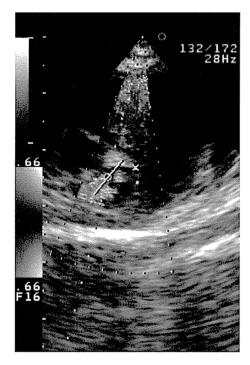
Echocardiography of right ventricular outflow tract. This finding showed the pulmonic valvular stenosis.
